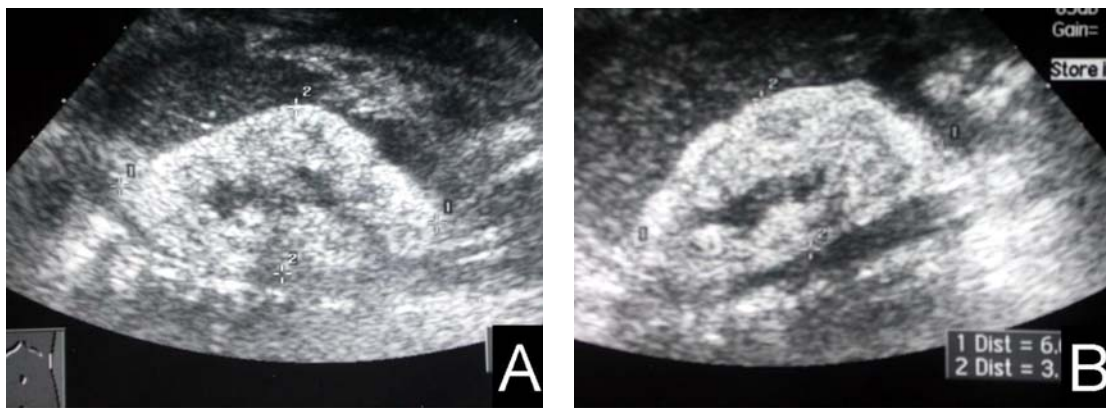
(A) Ultrasonogram of the left kidney and (B) the right kidney demonstrates normal sized with bilateral hyperechoic kidneys
